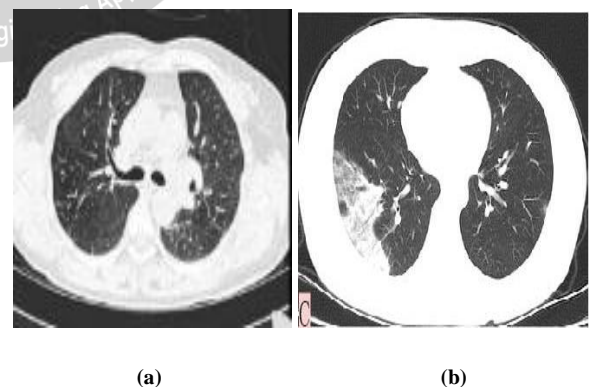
CT-Scan of Healthy Patient (a) vs CT-Scan of Covid-19 Positive Patient (b).
